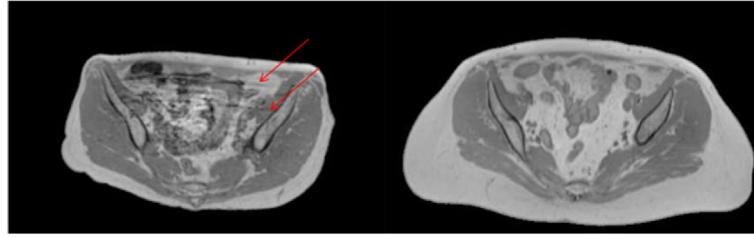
Example T1-weighted MR images used for this study with different image qualities. Left: image that shows motion artifacts (lines indicated by red arrows). Right: image of relatively high quality.
